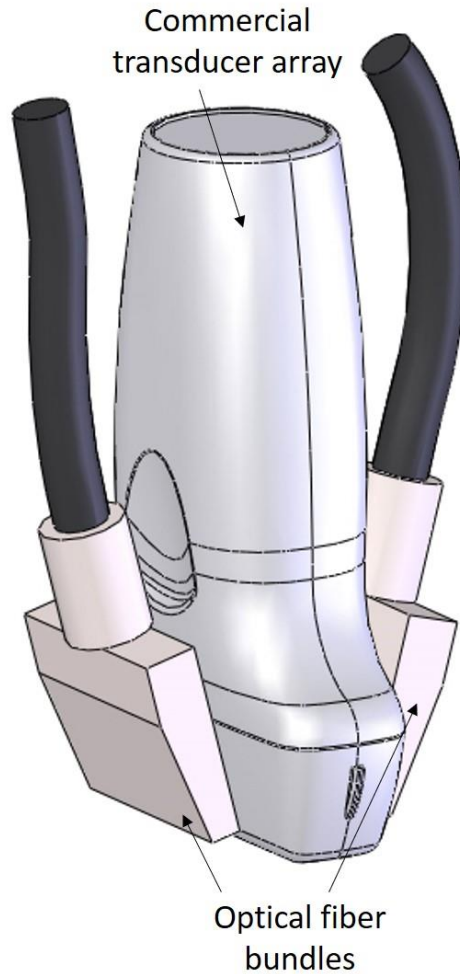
Representative image of the experimental setup commonly used for combined ultrasound and photoacoustic imaging. It consists of a linear ultrasound transducer array and light delivered from the side externally with bundles of optical fibers.
